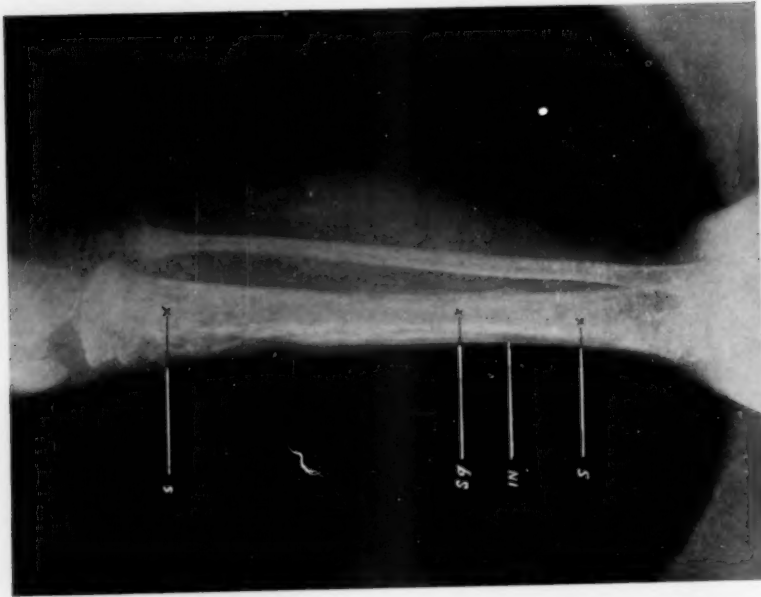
Clinical case No. 10. X-ray December 8, 1919. previous to operation. *Sq*, sequestrum; *In*, involucrum; *S*, separation zone.
